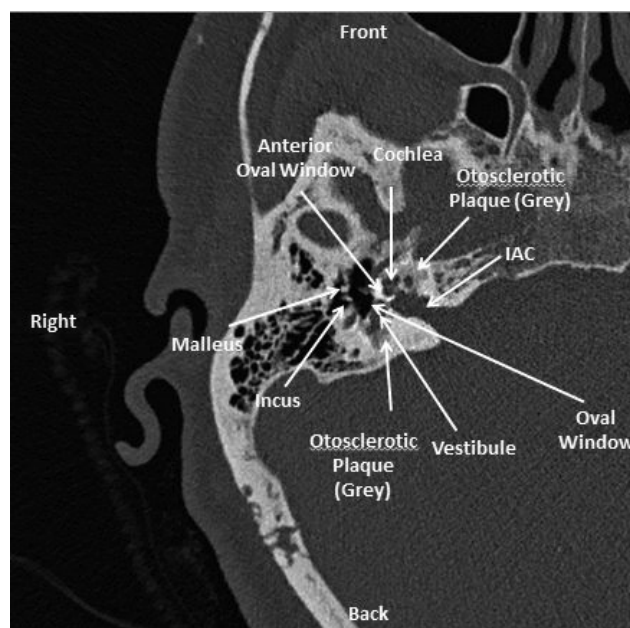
and Figure 1B. Axial CT image of the right (A) and left (B) temporal bones demonstrating cochlear and vestibular involvement by otosclerosis (gray blotches). The fissula ante fenestram (the anterior part of the oval window) is not involved and appears bright white as normal cochlear bone should be.
